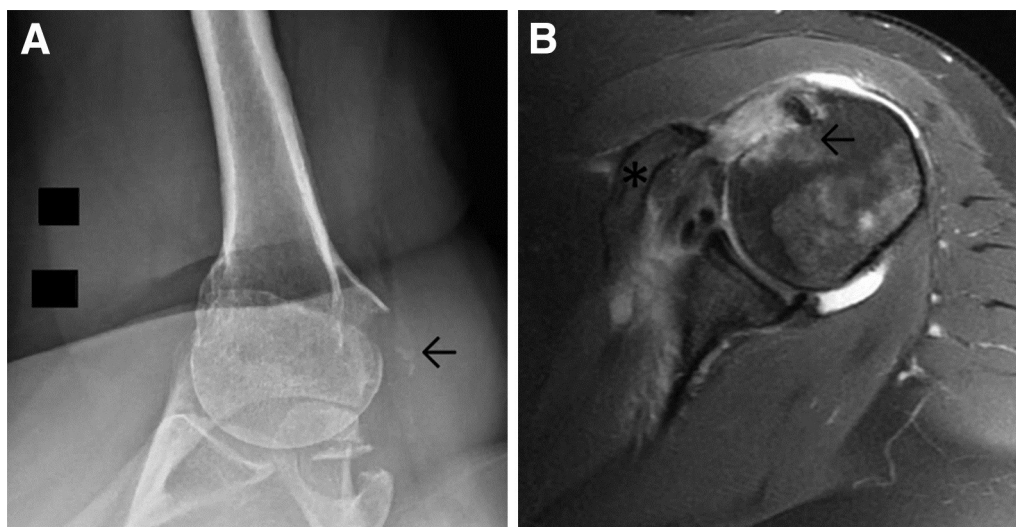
(A) Axillary view radiograph of a left shoulder demonstrating an avulsion fracture (arrow) of the lesser tuberosity. (B) Axial cut of T2-weighted magnetic resonance imaging of a left shoulder demonstrating an avulsion and retraction of the lesser tuberosity with the attached subscapularis tendon (asterisk) and associated humeral head bony edema (arrow).
